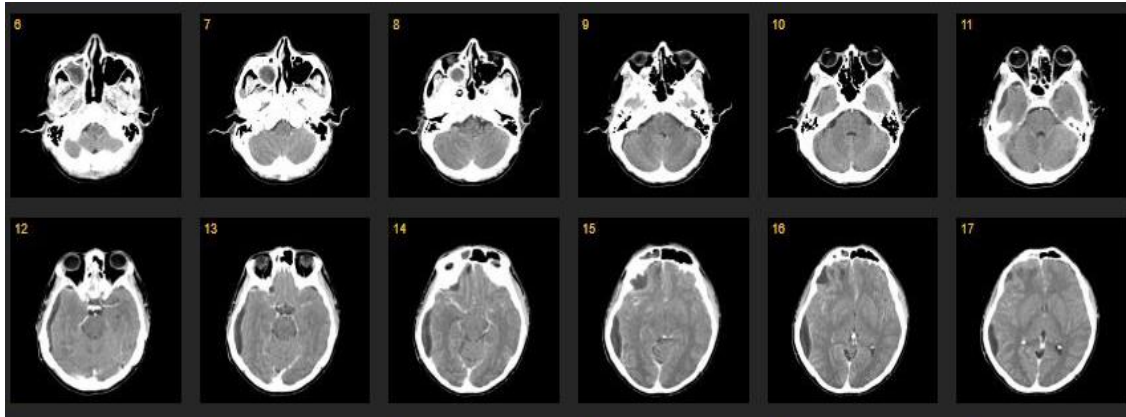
Contrast-enhanced head computed tomography showing a right frontoparietotemporal crescent-shaped subdural collection with peripheral enhancement, accompanied by cerebral edema and mass effect with midline shift. Opacification of the right maxillary sinus was also observed, supporting a sinogenic source of infection.
